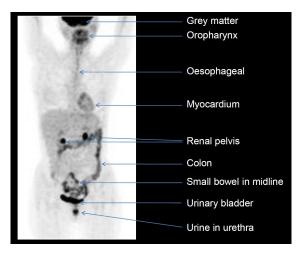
Normal distribution of FDG. (Image was obtained from [12])
